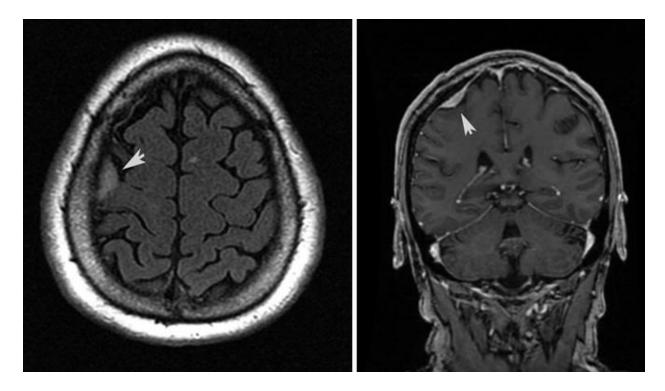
Example of incidentally discovered meningioma. FLAIR scan (left panel) of this 68-year-old
